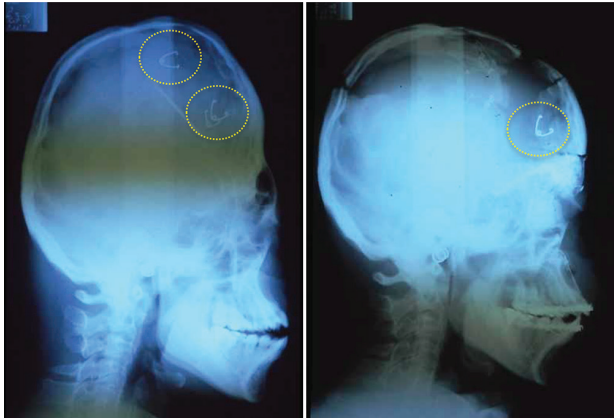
A proof of the earliest Japanese spring therapy; A 17 year-old female with Apert syndrome underwent a forehead and mid-face advancement in 1989. Pre and post-operative X-ray shows springs (yellow dot circle) on the calvarium.
